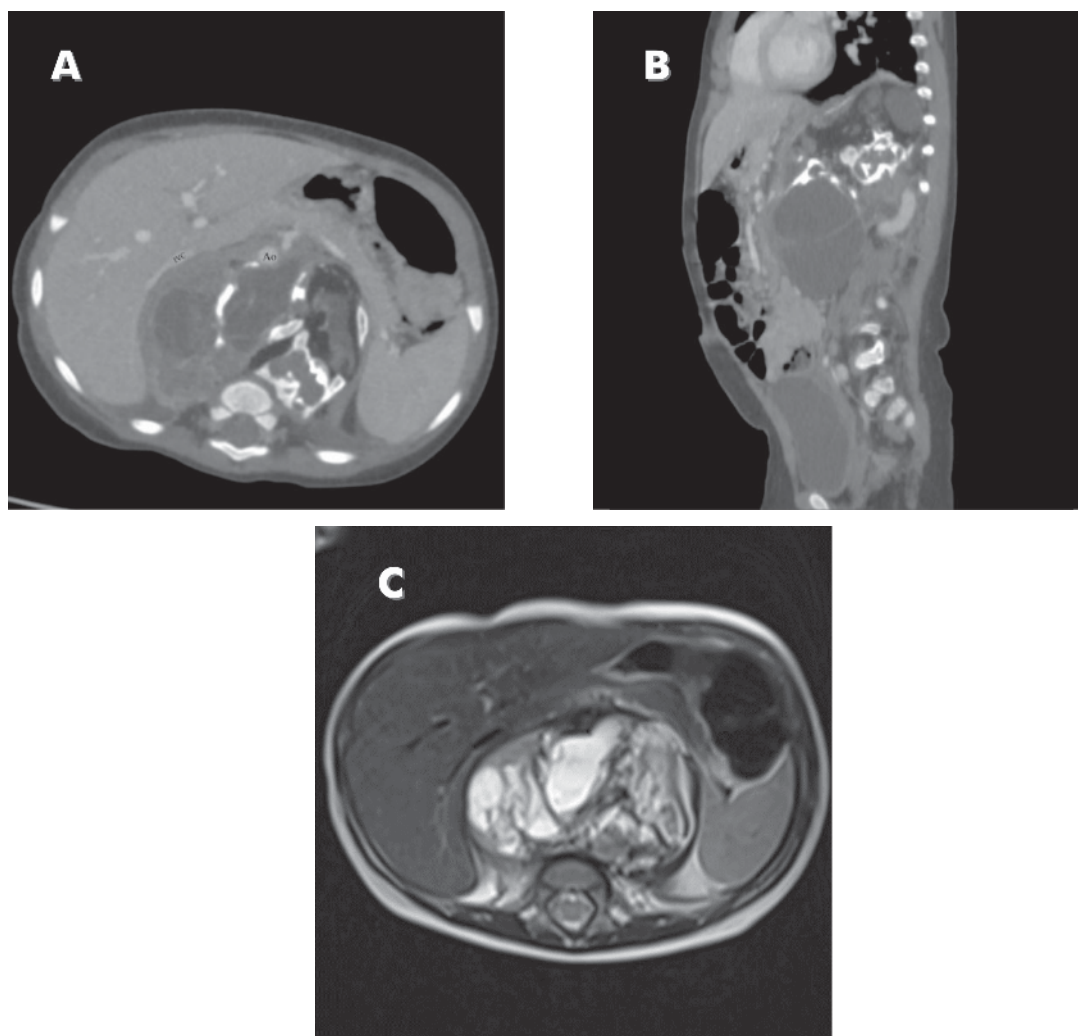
Figure (A): Axial Contrast CT scan shows fairly defined heterogeneously enhancing retroperitoneal mass. There is internal fat, fluid, and calcification. It is seen displacing aorta (Ao) and IVC anteriorly.
